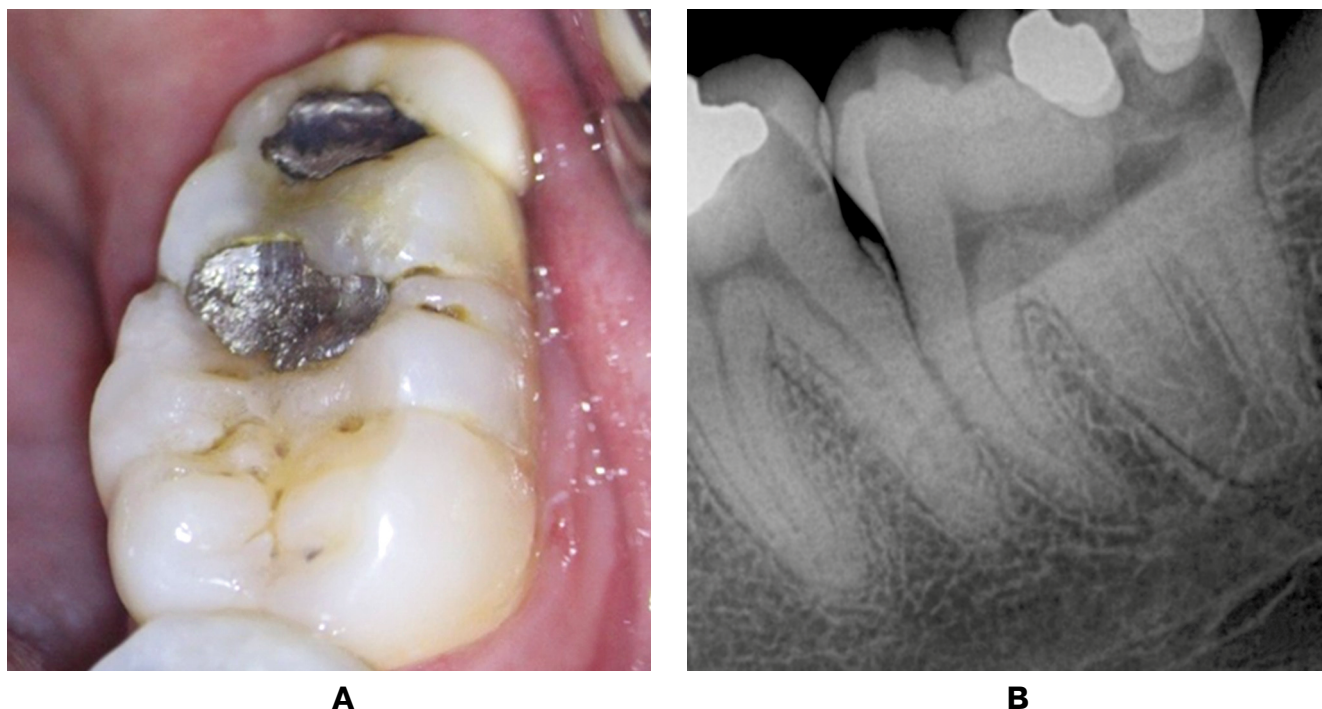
Third molar and a supernumerary tooth (distomolar): A – clinical image; B – periapical radiograph
